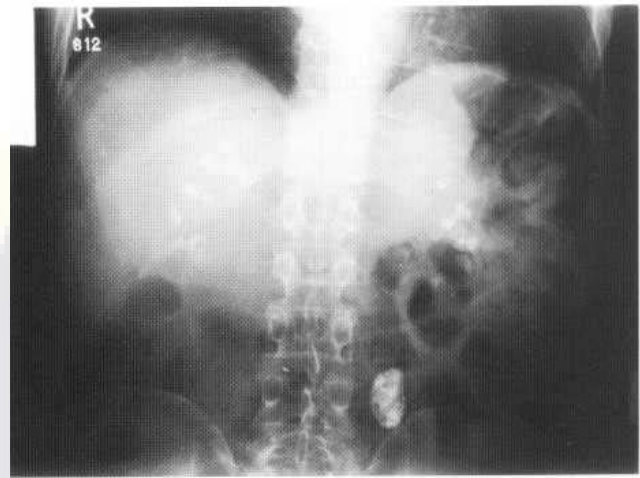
Plain film showing moderately dense nephrocalcinosis due to secondary hyperoxaluria.
